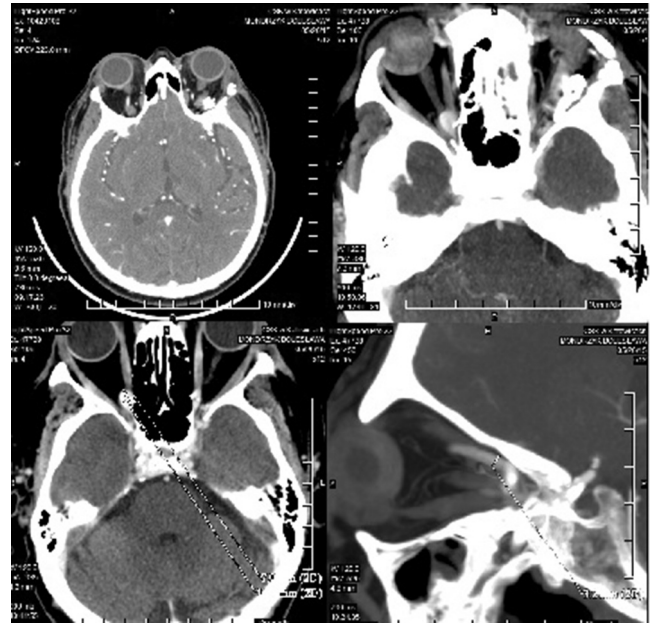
The follow-up CT angiography (four months after surgery). The top scans show clipping and complete excision of the aneurysm. The bottom scans show a small AVM in the apex of the right orbit.
